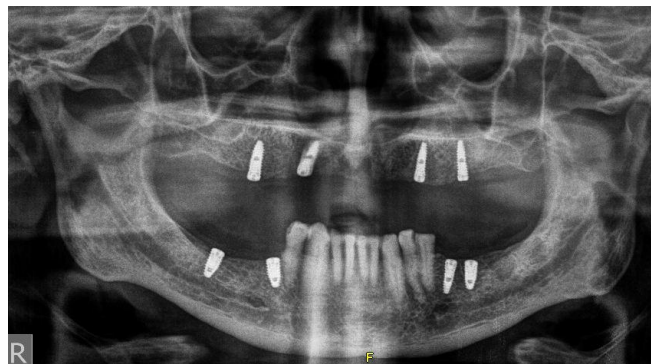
Post Implantation Orthopantomograph
